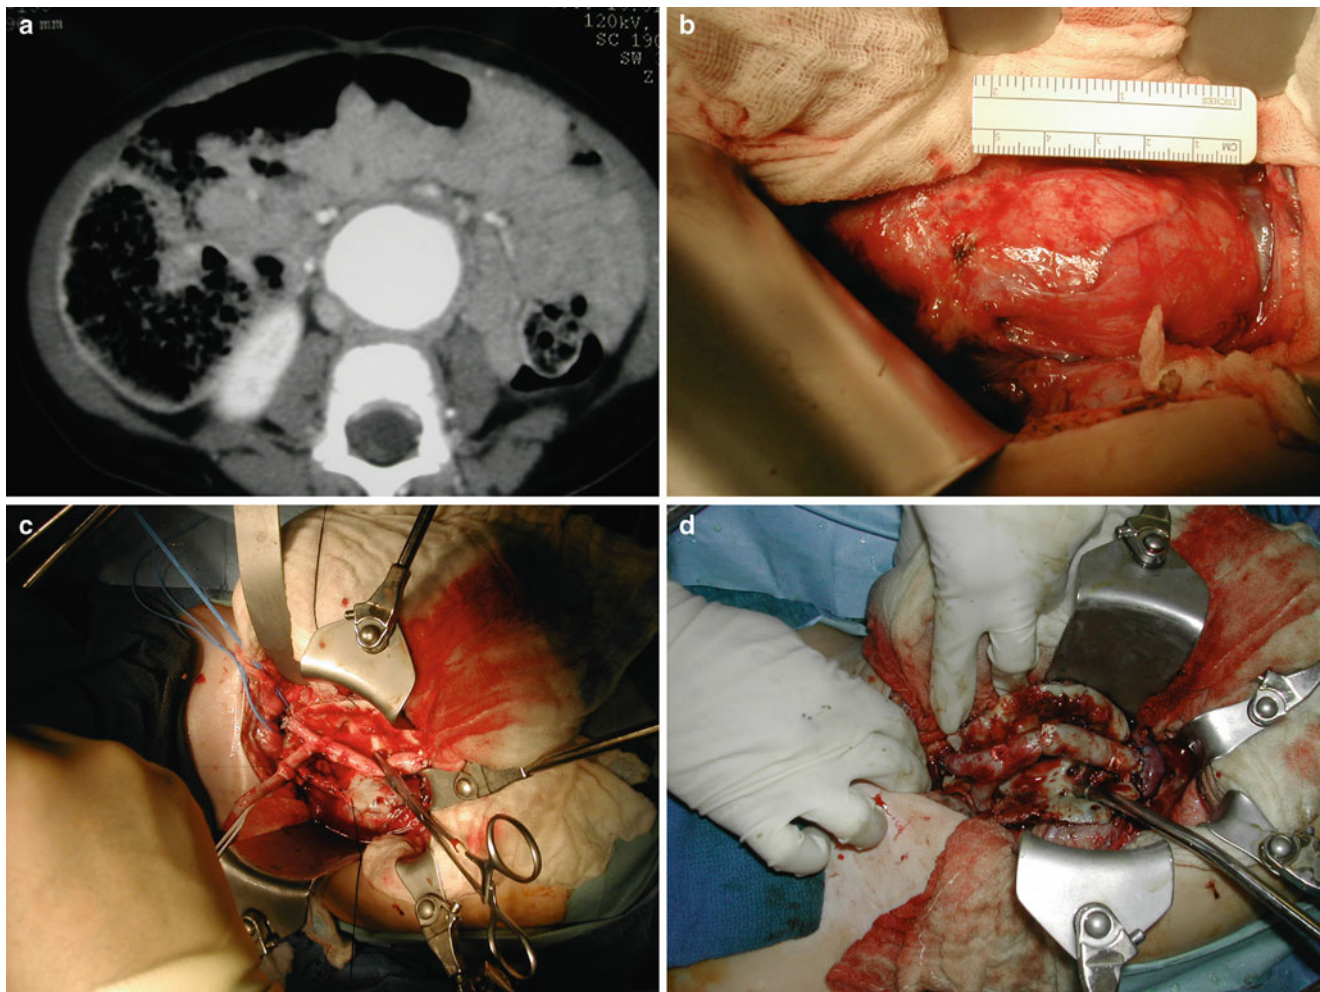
(a) CTA abdomen of a 14-month-old child with abdominal aortic aneurysm. (b–d) Intraoperative photographs of aneurysm repair with cryopreserved aorto-iliac arterial allograft. (b) Exposed infrarenal
